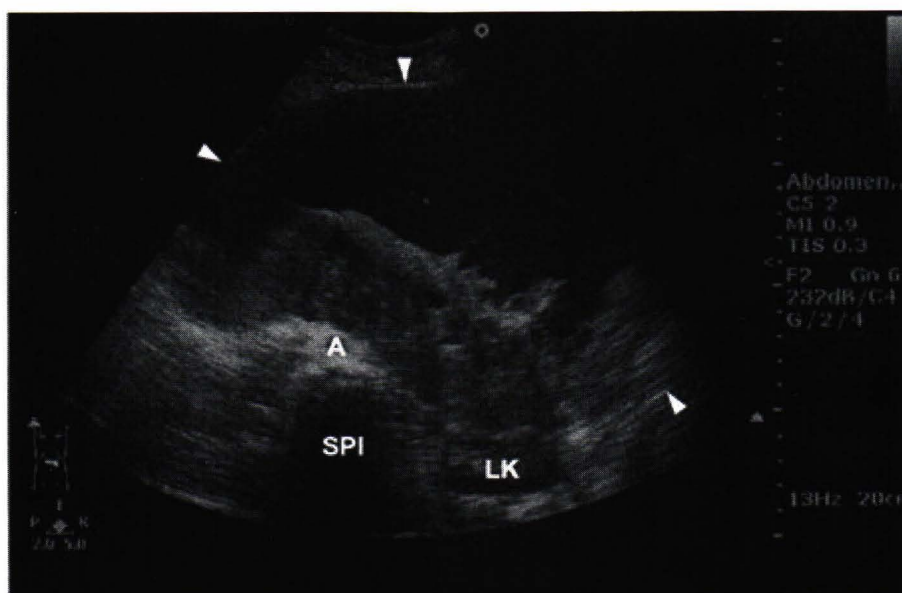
Ultrasonography of the upper abdomen shows a large complex mass (white arrow heads) with hypoechoic soft tissue component posterior to the epigastrium anterior to the aorta (A), compressing and posteriorly displacing the left kidney (LK). (SPI) = spine
